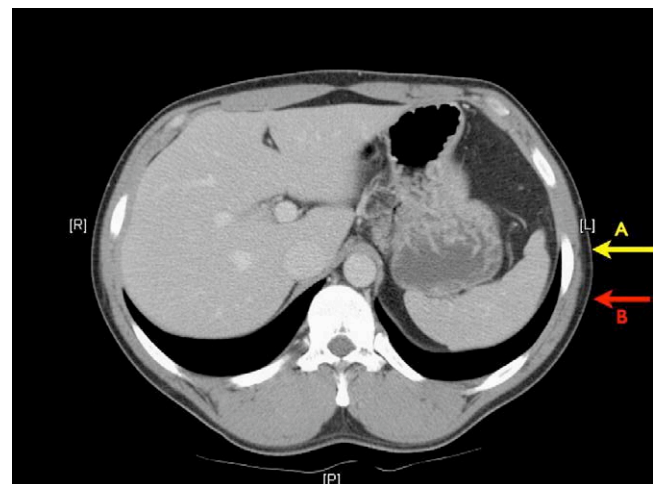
Computed tomographic image of patient. A, Anterior ultrasound probe position may show gastric flexure/gastric fluid sign on ultrasound. B, Posterior ultrasound position allows for imaging in a more dependent position and reduces the chances of visualizing the gastric flexure/gastric fluid sign.
